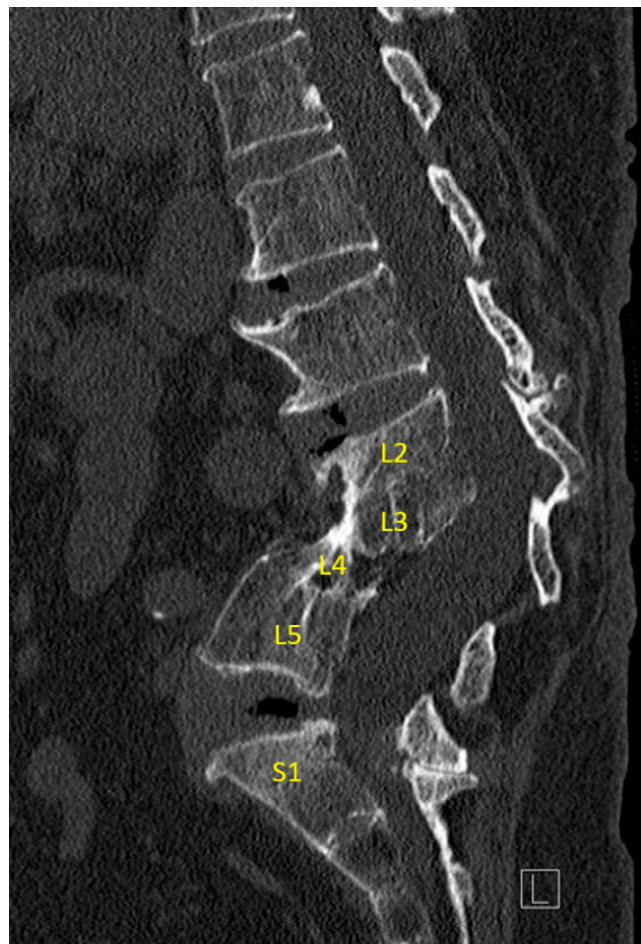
Preoperative sagittal CT of the lumbar spine without contrast shows multilevel spondylosis as well as severe deformity of the lumbar spine predominately involving acute kyphosis of L2-5, deformity of vertebral bodies, and osseous bony bridging, likely secondary to reported history of Pott's disease.
